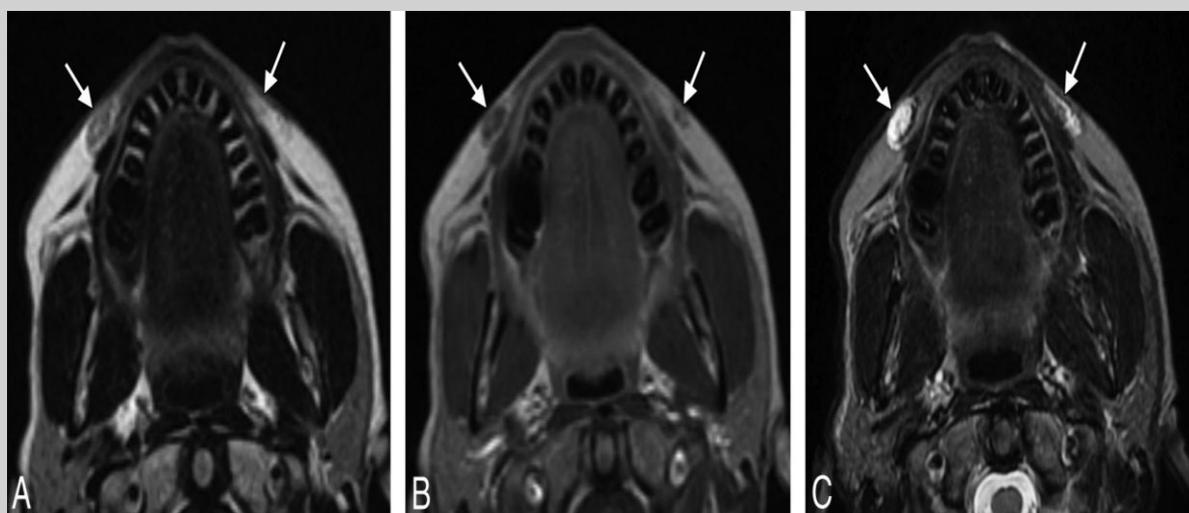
Axial post-contrast MR images in T1 (A, B) and fat-suppressed T2 (C) sequences demonstrate bilateral fluid-like accumulations in the nasolabial folds, more prominent on the right than on the left (arrows).
